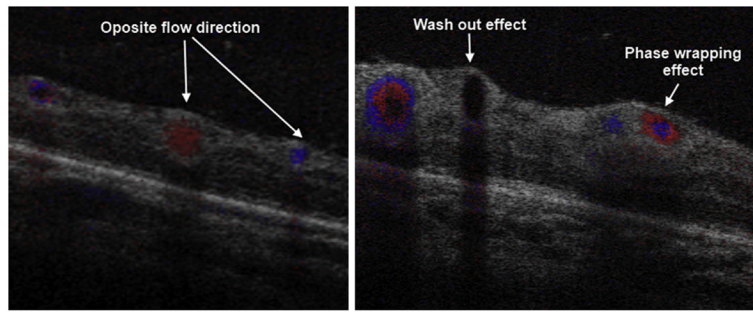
SDOCT color Doppler imaging in a 42-week-old PMA infant. The volumetric scan was of 5×5 mm, 500 A-scans/B-scan, 40 B-scans and 5 Doppler samples (5 repeated A-scans at each single A-scan point). The B-scans shown were located in zone I across the temporal/superior vascular arcades. (*Left*) B-scan distal to the optic nerve. Red and blue represent vascular flow in opposite directions with respect to the OCT beam. (*Right*) B-scan more proximal to the optic nerve. Red and blue rings are produced by increased flow velocity. At higher flow velocities, the Doppler signal disappears, a phenomenon known as washout effect.
